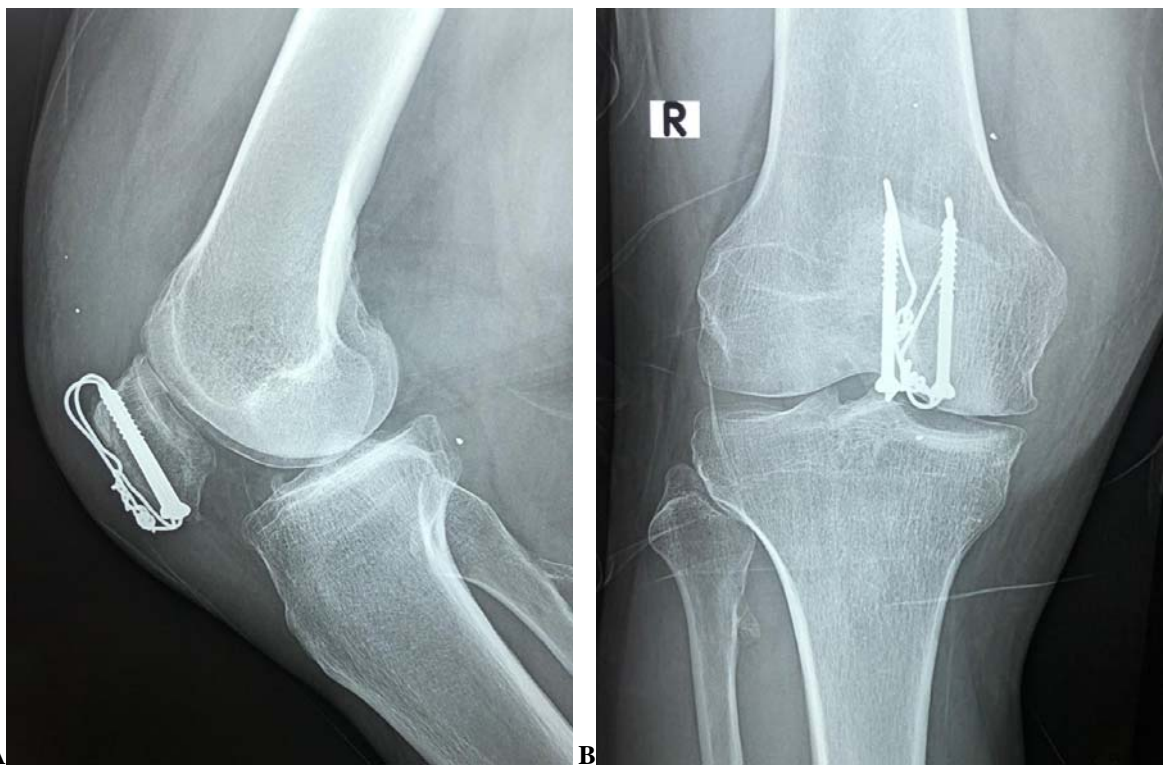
Two-month postoperative lateral radiograph for a female patient 50 years old (case no. two), with a transverse fracture patella fixed with the technique described. B: Two-month postoperative AP radiograph of case no. two.
